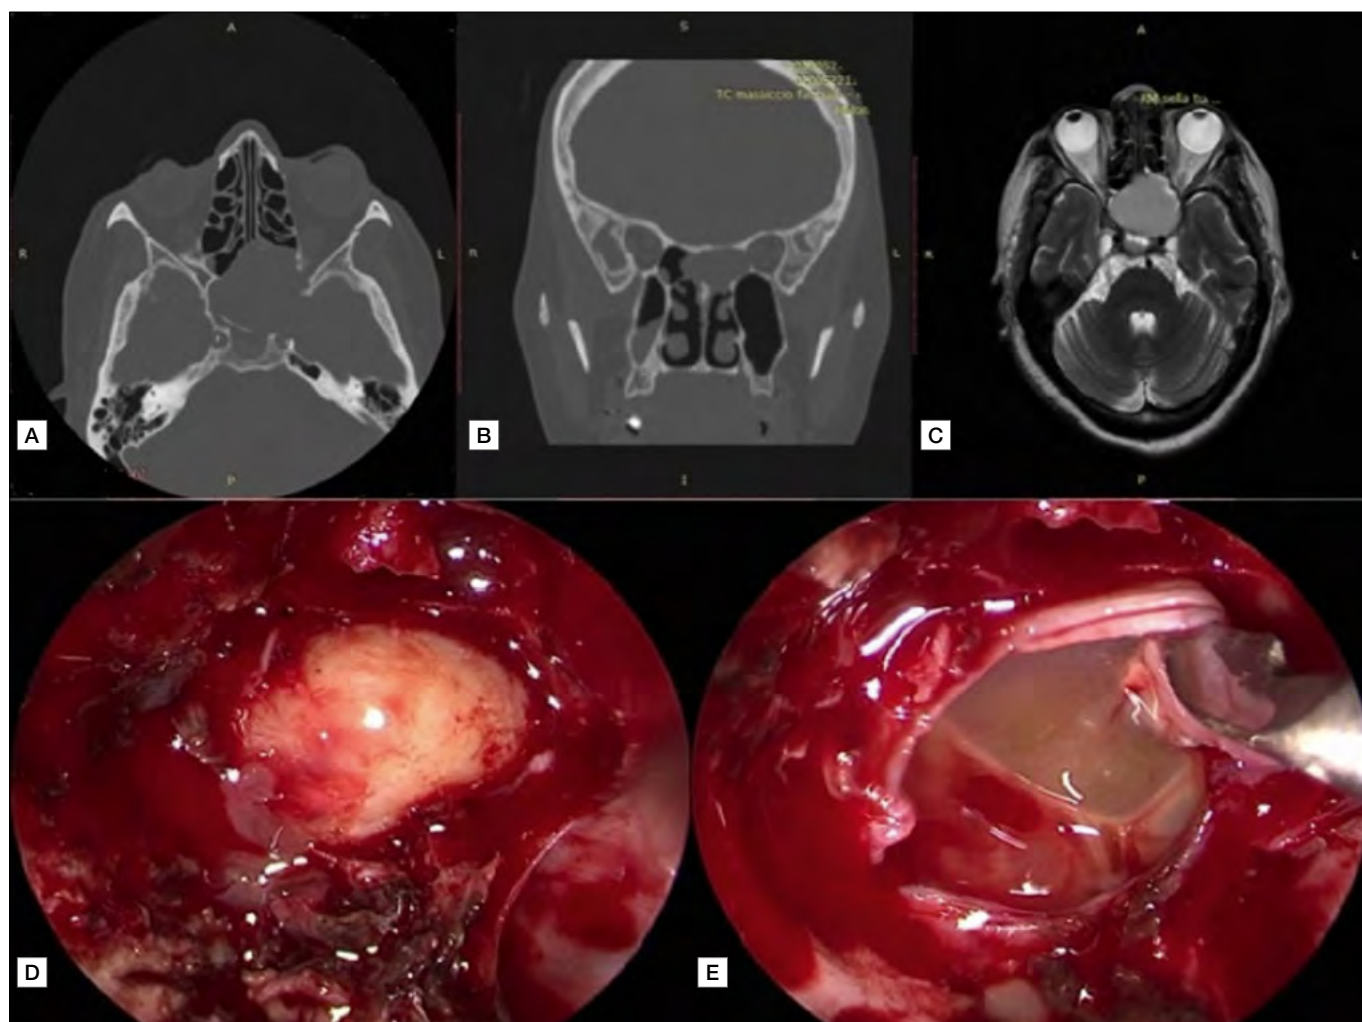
CT scan (A and B) and MRI (C) of a sphenoidal mucopyocele with bone erosion of optic foramen, lamina papyracea, orbital apex, carotid canal and sella turcica. Intraoperative view of the mucopyocele sac before (D) and after (E) its endoscopic drainage.
